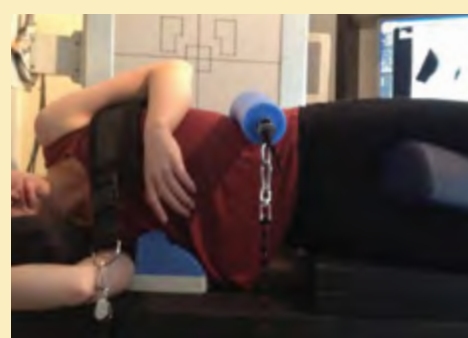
Shown on the left is the three-point Stress radiography setup on the denneroll table with 2 blocks placed under the right side of the pelvis to create thoraco-lumbar translation. Note the improvement in the appearance of the lumbar curve while simultaneously decreasing the thoracic curve.
